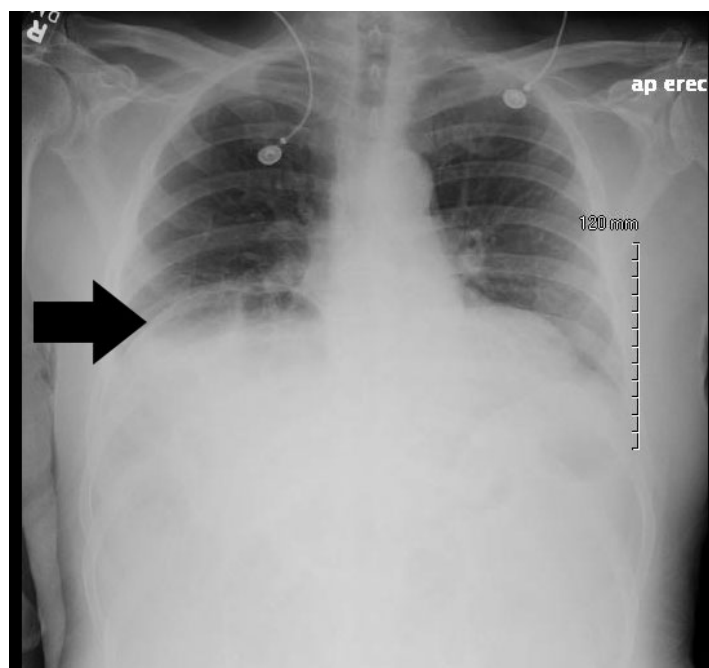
Upright chest radiograph demonstrating Chilaiditi sign (pseudopneumoperitoneum) mimicking apparent free intraperitoneal air under the right hemidiaphragm.
